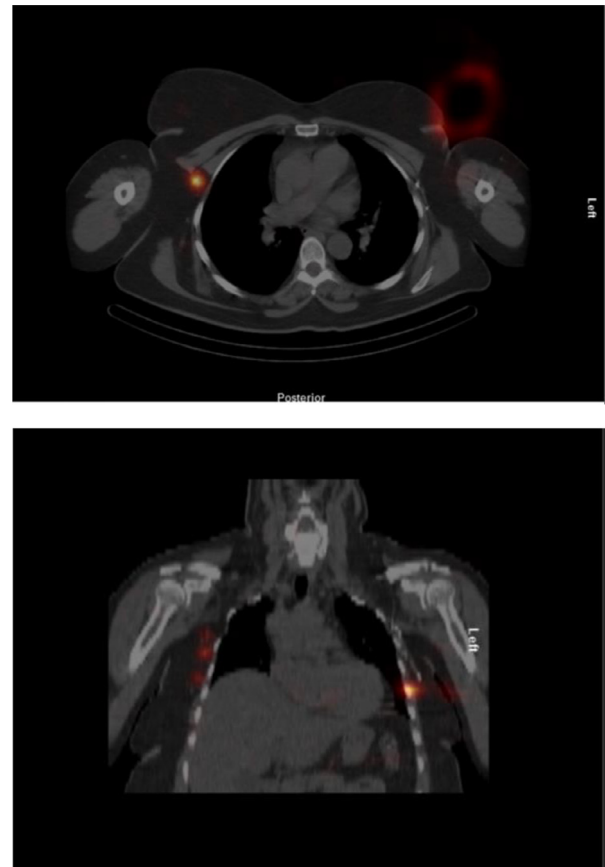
Pre-operative lymphoscintigram showing radioisotope injected into the left breast with recurrent cancer, identifying a sentinel node in the contralateral right axilla.
